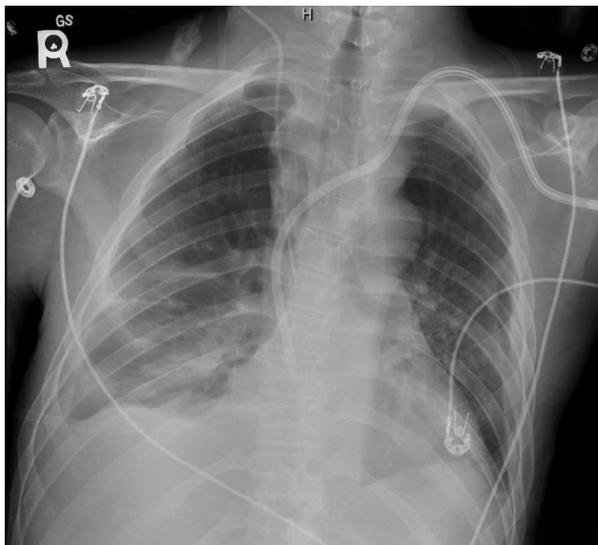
Follow-up CXR showed marked improvement of pulmonary infiltrates. CXR, chest X-ray.
